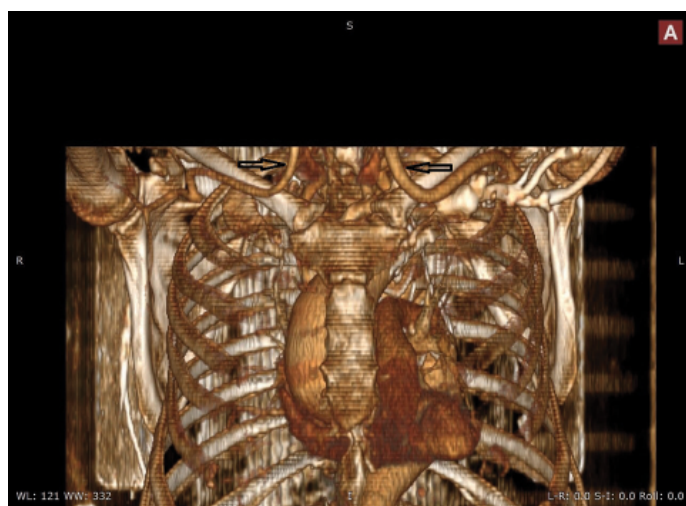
Postoperative CT angiographic view (arrows indicate extra-anatomic bypass grafts)
